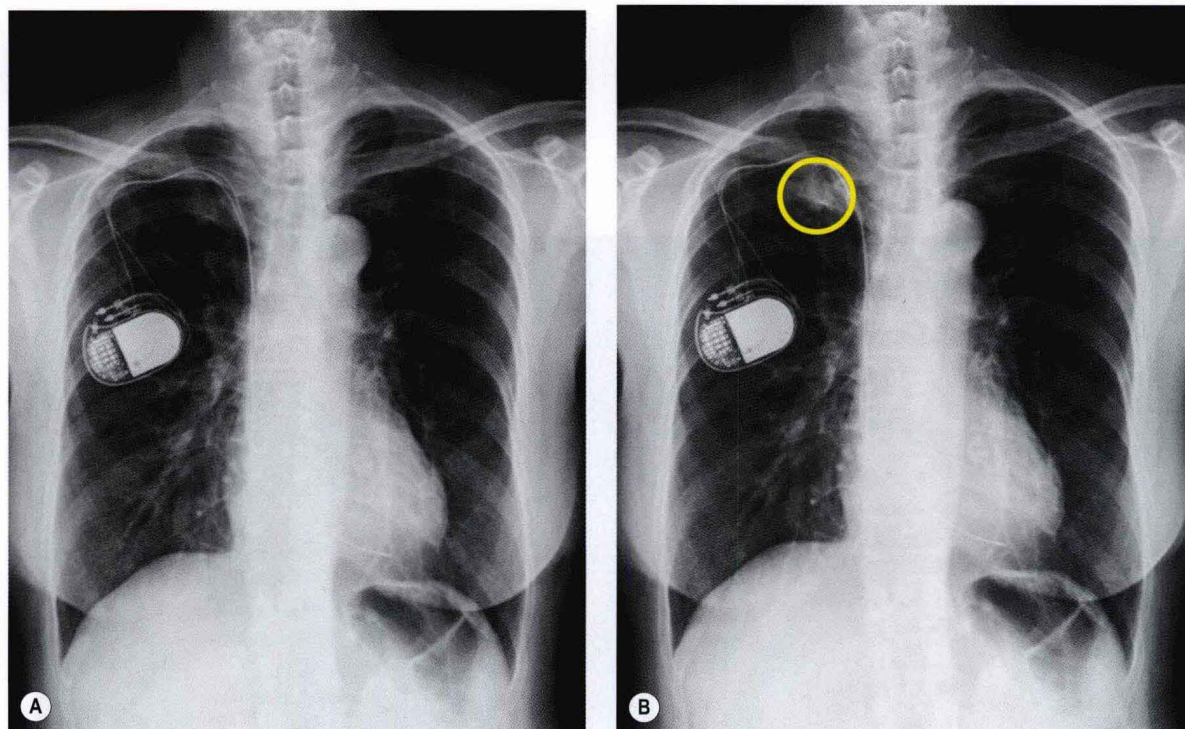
Computer-aided detection (CAD). A, Chest radiograph shows a lung nodule correctly identified by CAD shown in B (yellow circle), despite being directly adjacent to the lower margin of the first rib.
